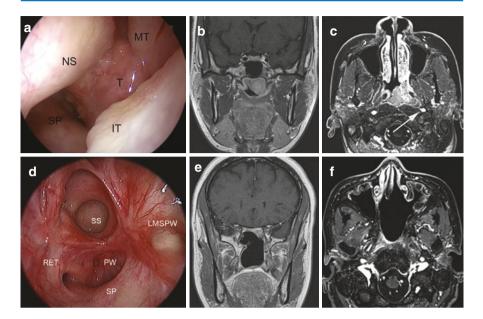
Pre-treatment nasal endoscopy (a) and MRI in coronal (b) and axial (c) planes showing a nasopharyngeal AdCC with no critical relationship with the left ICA (arrow in c) and no intracranial extension. The patient was treated by transnasal endoscopic nasopharyngectomy (NER Type 3) [77] and adjuvant radiotherapy. Nasal endoscopy (d) and MRI on coronal (e) and axial (f) planes show no signs of local recurrence at 7 years after treatment (*IT* inferior turbinate, *LMSPW* left maxillary sinus posterior wall, *MT* middle turbinate, *NS* nasal septum, *PW* posterior nasopharyngeal wall, *RET* right eustachian tube, *SP* soft palate, *SS* sphenoid sinus, *T* tumor)
